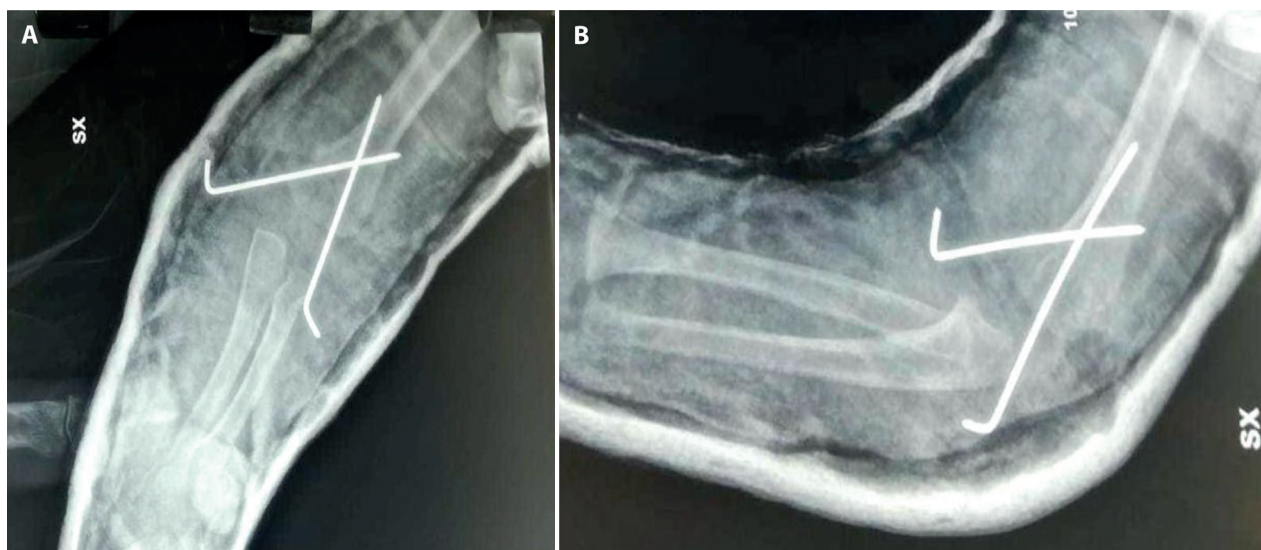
Postoperative radiograph in frontal and lateral view of left humeral supracondylar fracture treated with 2 crossed K-wires.
